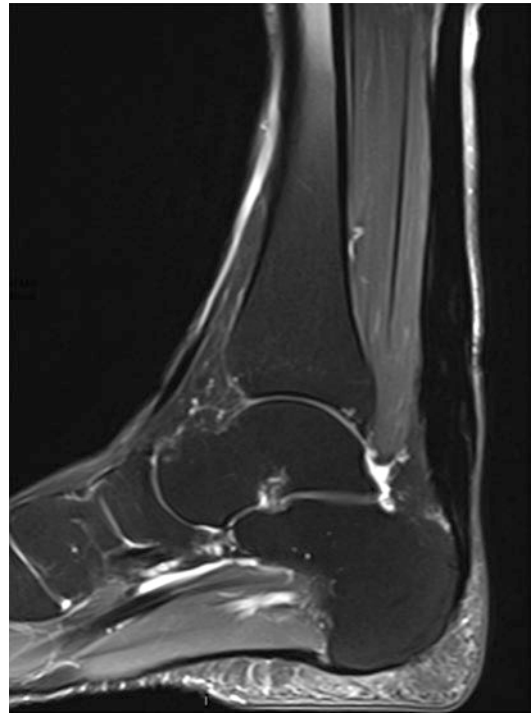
A proton density fat suppressed MRI showing a long segment of non-insertional Achilles tendonopathy
